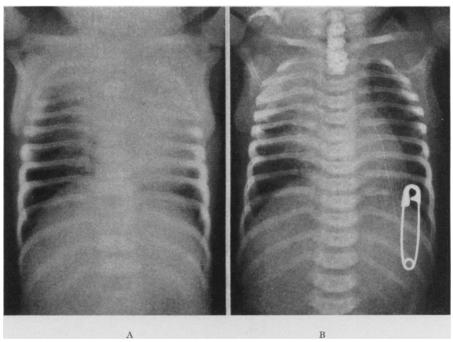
V. L., Case 22.—(A) Roentgenogram on admission shows small degree of involvement of right upper lobe and extensive involvement of left upper lobe. When the patient was turned to the right lateral position during the subsequent physical examination, reaeration of the left upper lobe occurred, demonstrating that the involvement of the left upper lobe was on the basis of atelectasis and not a pneumonia. Roentgenogram (B) was made immediately after the physical examination and three hours after roentgenogram (A). The left upper lobe is now clear. The infiltration in the right upper lobe which has persisted in spite of the use of the left lateral position during the physical examination is probably pneumonic in nature. Operation was undertaken one hour after roentgenogram (B). The right extrapleural approach was used because of the pulmonary involvement on the right. An anastomosis was completed and the patient is now living 13 months after operation.
